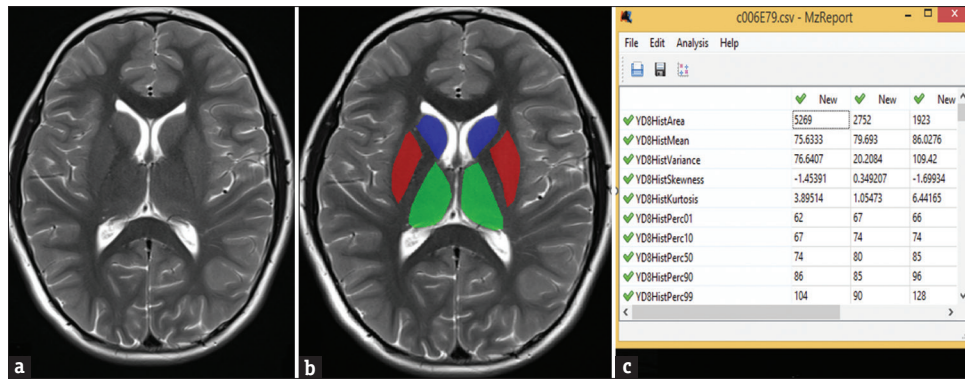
12-year-old male patient with primary nephrotic syndrome. (a) Ventricular level on T2-weighted axial brain MRI image. (b) Two-dimensional segmentation of the thalamus (green), lentiform nucleus (red) and head of the nucleus caudatus (blue) from the same level using qMazda V.6 software. (c) Quantitative values of the histogram parameters of the area determined in image B.
